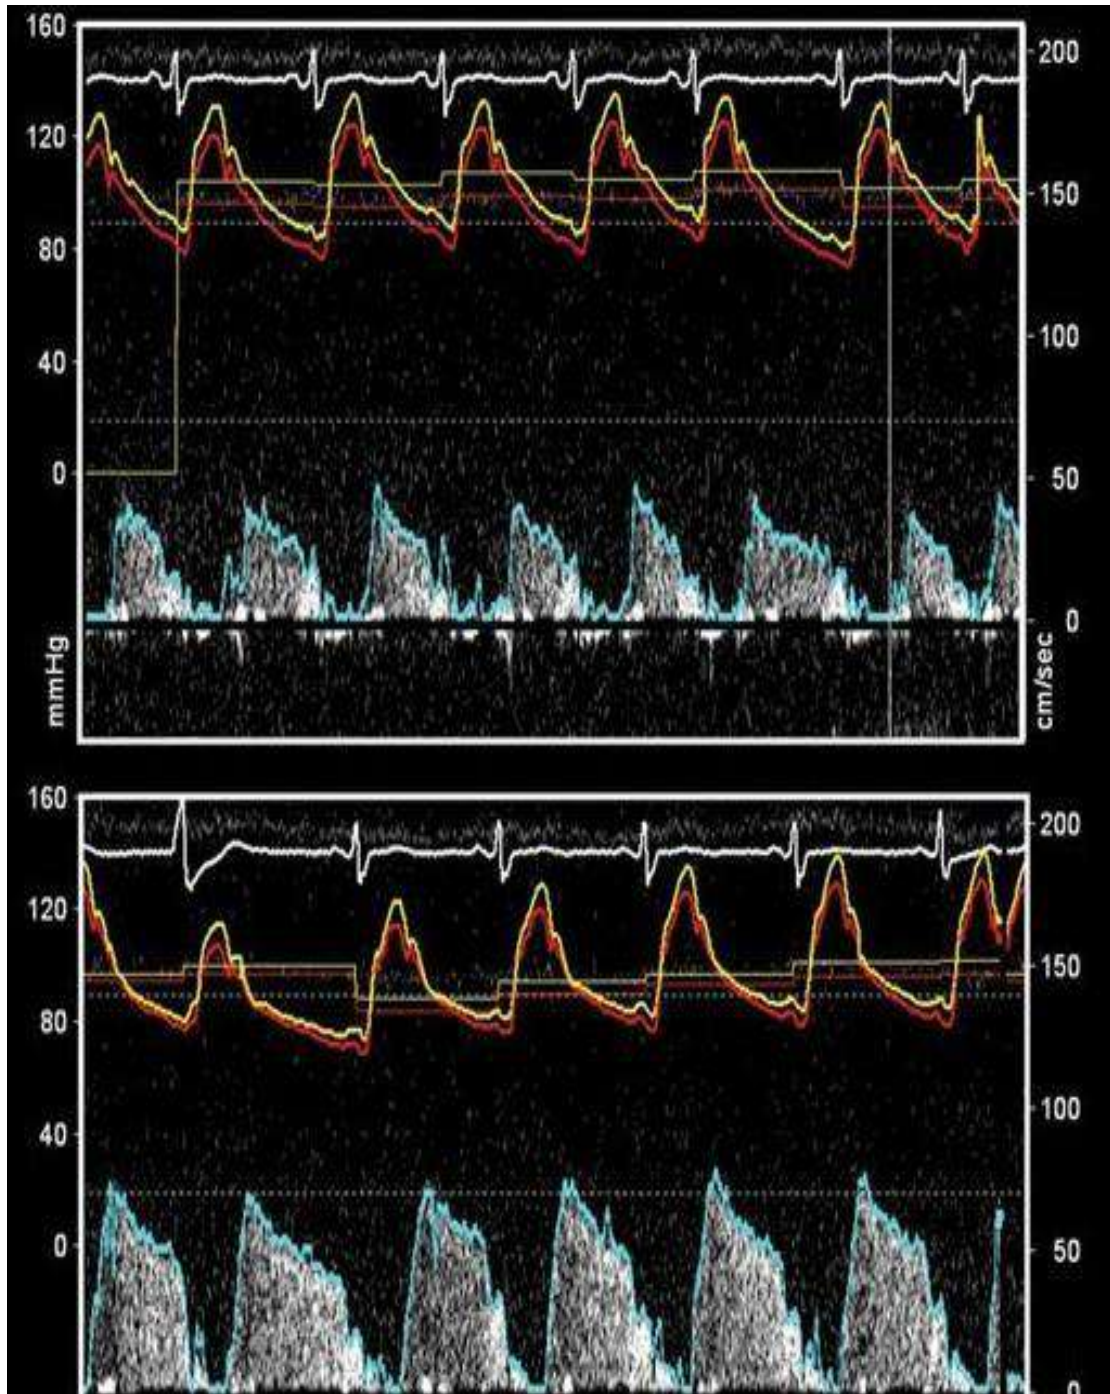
Resting (top) and hyperaemic (bottom) coronary flow velocity by intracoronary Doppler. Adapted with permission from Amier *et al.*(158)
